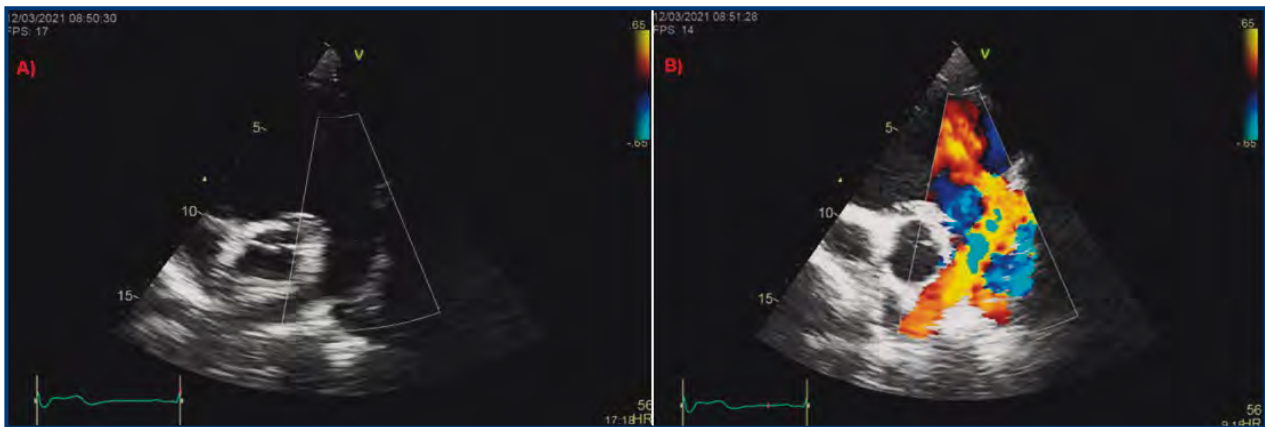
Transthoracic color Doppler echocardiogram. Short axis at the level of great vessels. A. Pulmonary valve is absent. B. Color Doppler shows severe pulmonary regurgitation.
